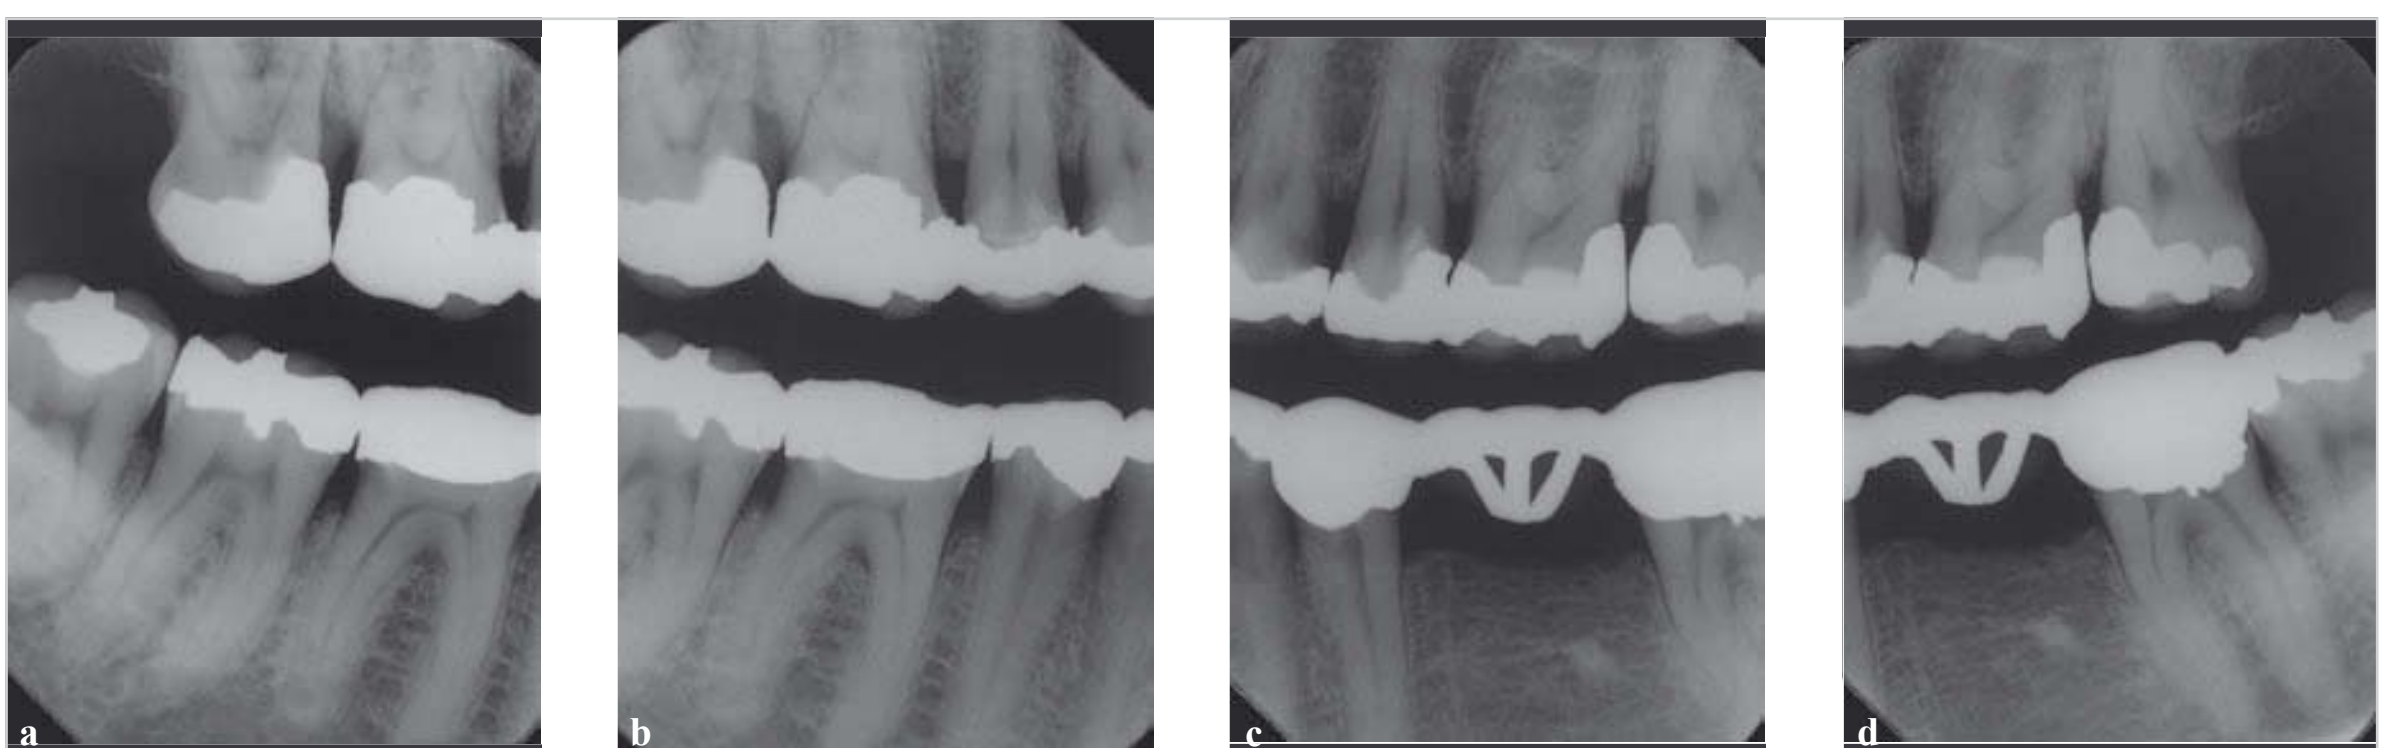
Vertical bitewings provide a view of the crowns and alveolar bone.
